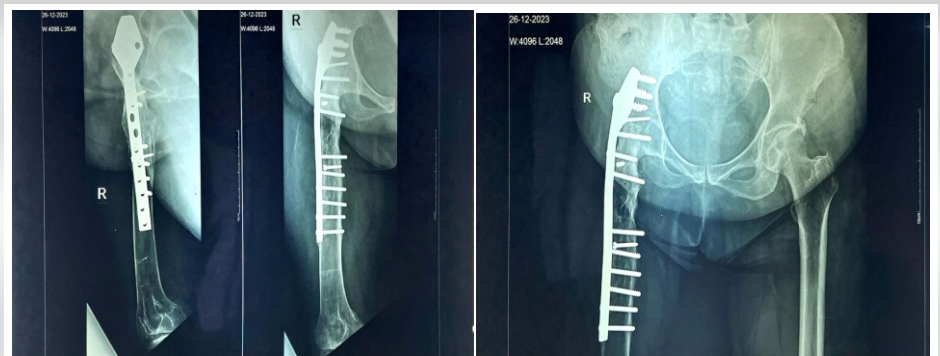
Follow-up radiograph in 2023.
